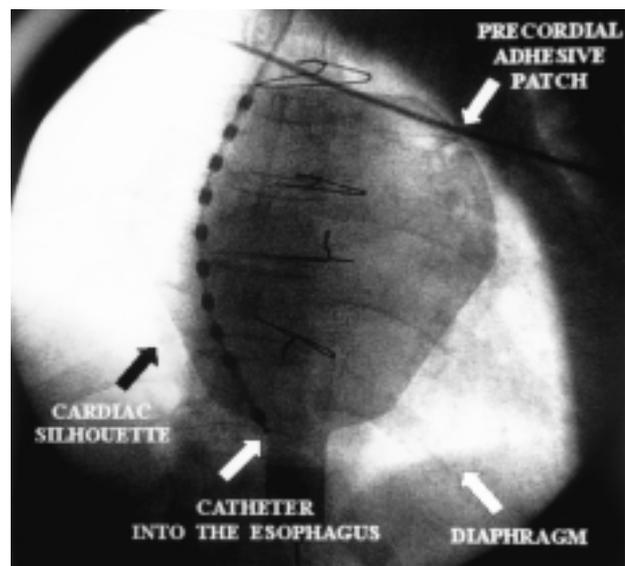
Radioscopic view of the transesophageal catheter into the esophagus.
